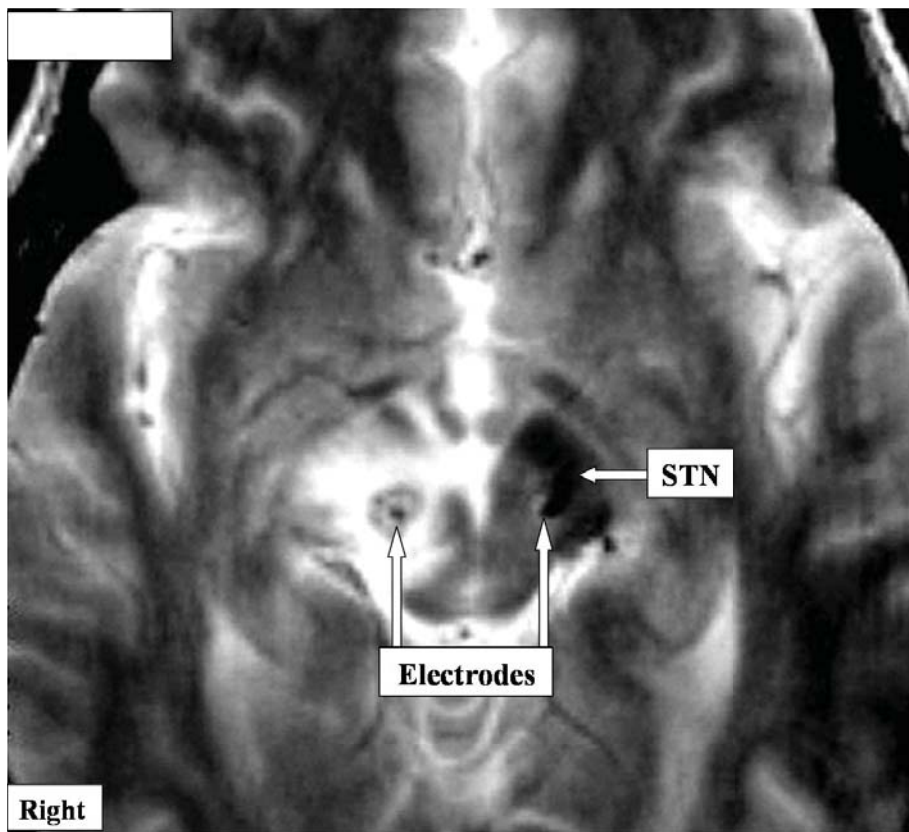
T2 weighted MRI showing oedema as a sign of inflammation along the right electrode. *(Reprinted with kind permission from the publishers.¹⁵⁹)*
